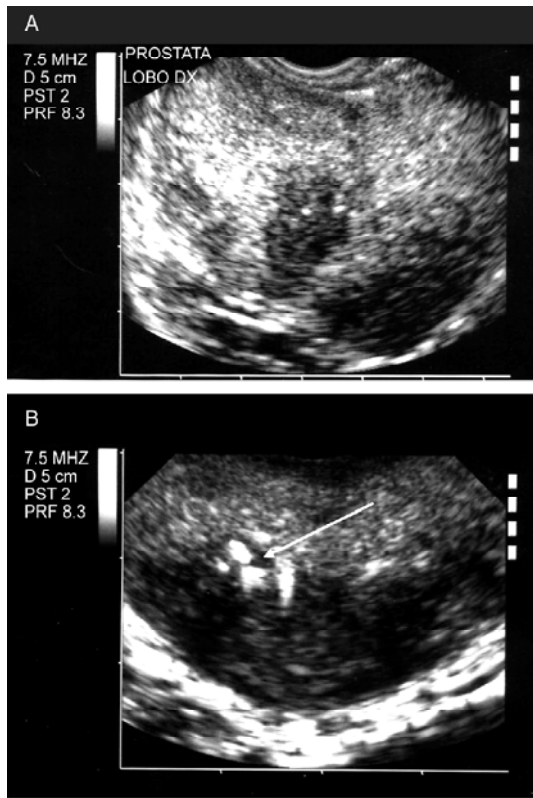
(A): Representative photographs of patients with ultrasound aspects of prostate abscess (group A). (B): The presence of hypo-anechoic areas (arrow) surrounded by hyperechoic area is suggestive of a micro-empysematous abscess.
